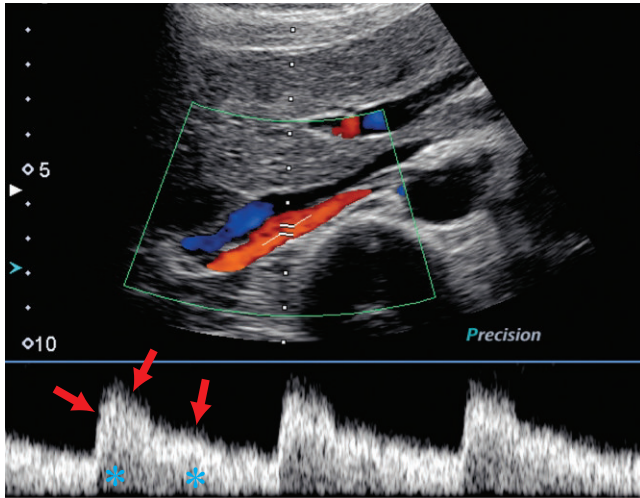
Main renal artery spectral Doppler shows normal spectral broadening. There is spectral broadening in the renal artery because the flow profile is parabolic. If one looks up and down at each time point there are signals at all velocities. In parabolic flow, the fastest velocity is in the center of the vessel and slows down gradually in the layers of flow that are closer to the vessel wall. Note the envelope (arrows) is whiter than the window but there are signals (filling in) of the spectral window in systole and diastole (*).
